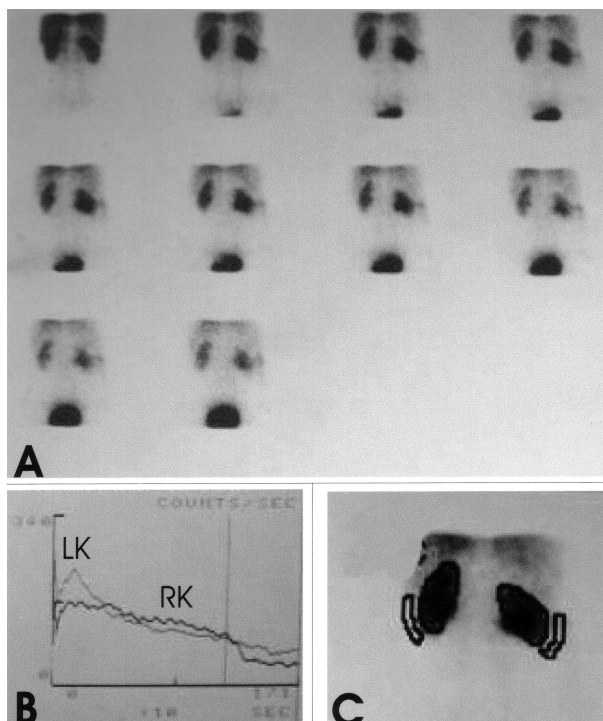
Postoperative renal scintigraphy in same patients (A). Renogram shows improvement in drainage (B). Differential renal function was increased from 39% to 44% in the right kidney. LK = left kidney, RK = right kidney.
